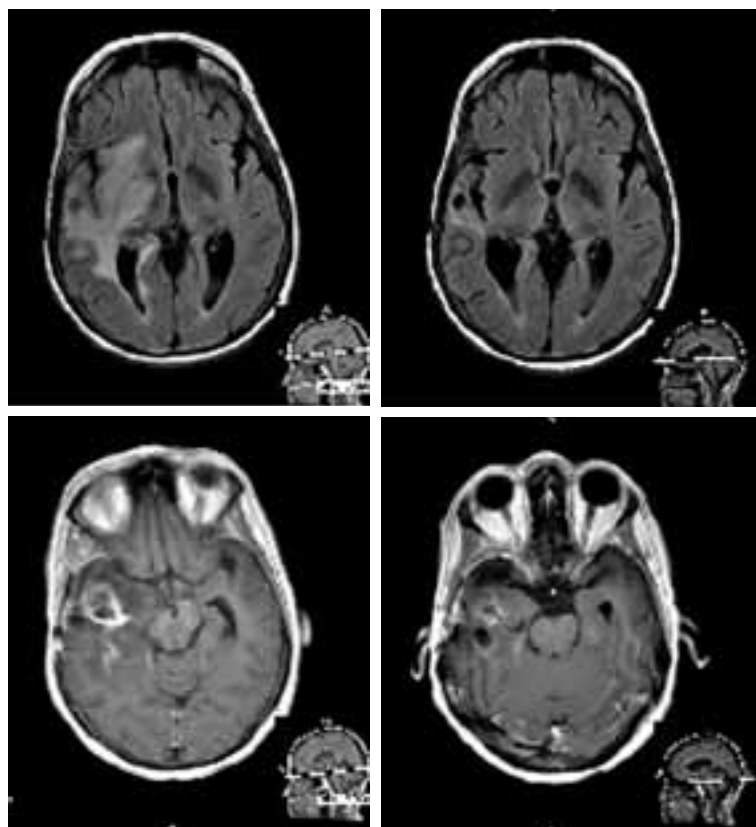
Image of glioblastoma/high grade glioma patient after three treatments with bevacizumab (Avastin) and CPT-11. The image on the left represents her magnetic resonance imaging prior to treatment, and on the right is her more recent study. The image taken after treatment (on the right) demonstrates a reduction in both the tumor size as well as the surrounding vasogenic edema associated with the tumor. The patient's symptoms improved accordingly.
